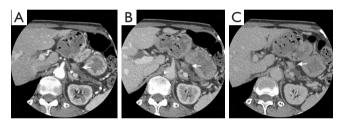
Dynamic CT showing a pancreatic tumor. (A) Arterial phase; (B) portal phase; (C) delay phase. The pancreas is highly atrophic, and the pancreatic tumor is slowly enhanced (arrows).
